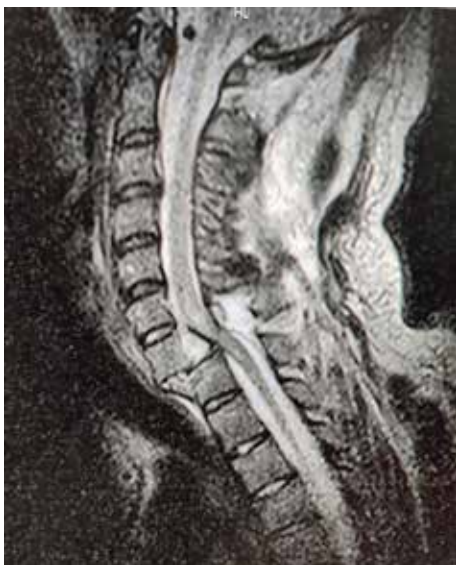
Magnetic resonance imaging of the cervical spine before surgery
